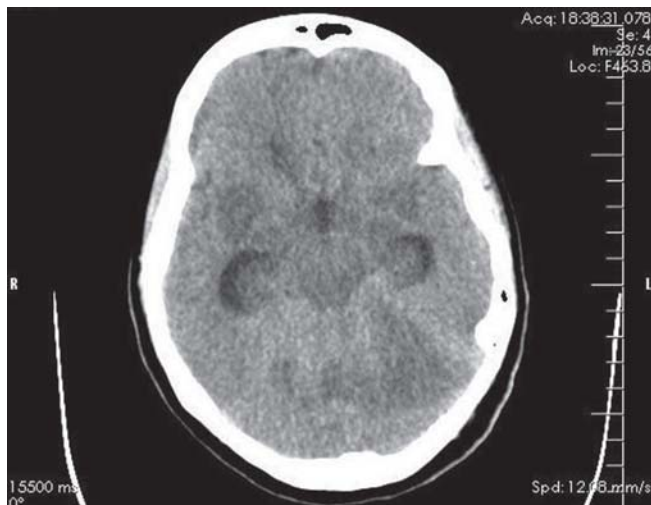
CT scan of the head
